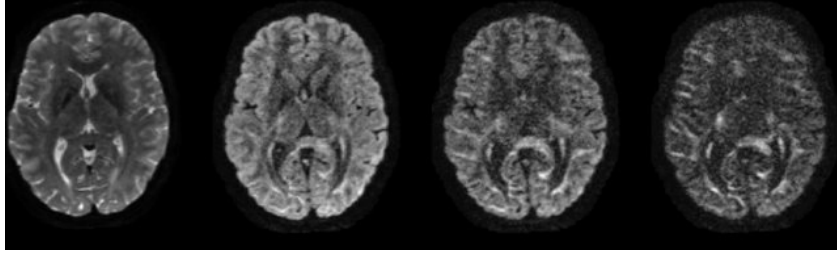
Brain DWI images in axial view, obtained using 4 different b-values (from left to right: 0, 1000, 2000, 3000 s/mm²). The signal attenuation as a function of the b-value can be noticed [Descoteaux, 1999].
